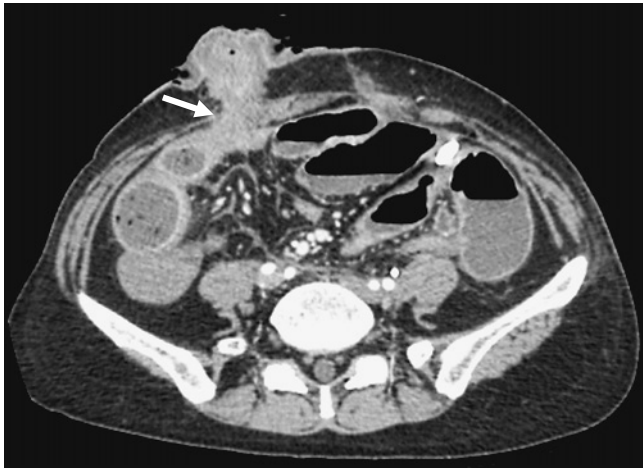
Computed tomography image of the case who develop outlet obstruction. The ileum just before the outlet site of ileostomy is dilated (arrow).
